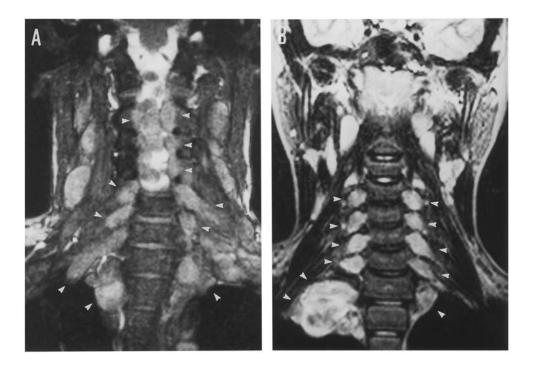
Coronal T2-weighted spinal MRI scan of patients II-3 and III-2. *A*, Patient II-3: multiple bilateral neurofibromas, at cervical and dorsal levels, with the intra- and extraspinal components of a dumbbell neurofibroma growing into both the brachial plexus and the apical region of the lung. *B*, Patient III-2: multiple bilateral, paravertebral tumors, from C2–C3 to D3–D4, and two paravertebral masses, in the right-and left-lung apical regions. The arrowheads point to some of the spinal neurofibromas.
